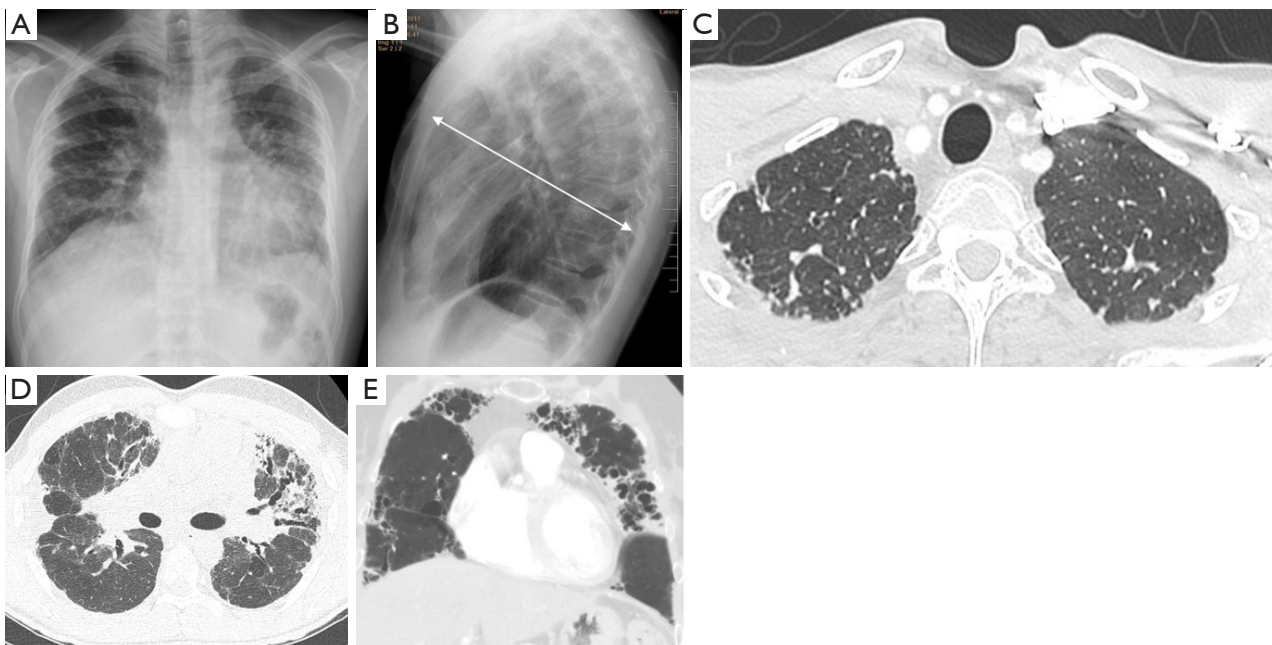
Pleuroparenchymal fibroelastosis. (A) Chest radiography shows upper-lobe volume loss, distortion of the pulmonary hila, as well as biapical pleural thickening. (B) Lateral view shows flattening of the chest, observed by the decreased anteroposterior diameter of the rib cage (arrow). (C) A prominent supra-sternal notch due to decreased volume in the upper thoracic region and ongoing weight loss (arrowhead). (D) HRCT and (E) HRCT coronal reconstruction section show pleural thickening and signs of pulmonary fibrosis, mainly in the left upper lobe, with multiple traction bronchiectasis, superimposed with ground-glass opacities. HRCT, high-resolution computed tomography.
